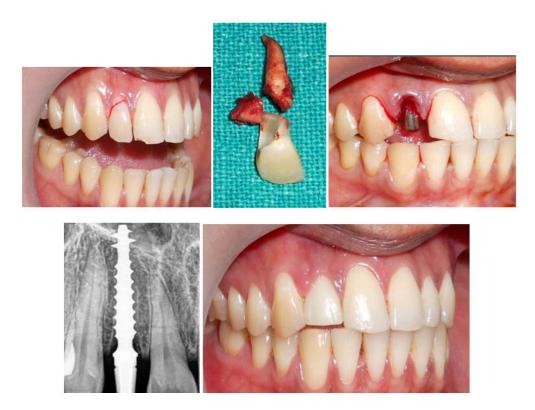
(a)Preoperative view-Fractured 12 (b)Extracted tooth (c)Single piece implant inserted (d)Post operative radiograph (e) Post operative clinical view with the final prostheses.
